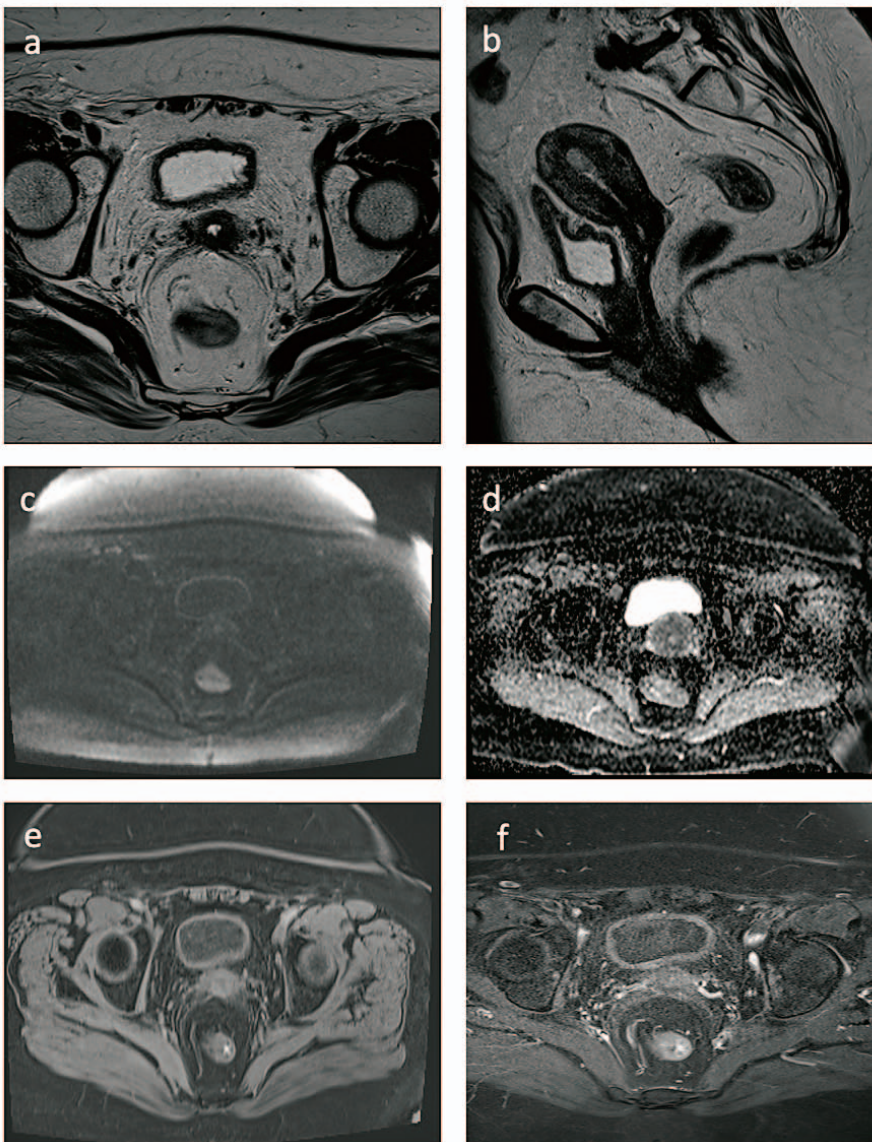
Post-treatment MRI scan: T2-weighted images in the oblique axial (a) and sagittal (b) planes show tumor regression. The intact hypointense stromal ring indicates regression of the parametrial invasion (PMI). Additionally, on DWI (c) and ADC map (d), no diffusion restriction is observed, corresponding to no pathological contrast enhancement on post-contrast T1-WI (e, f).
